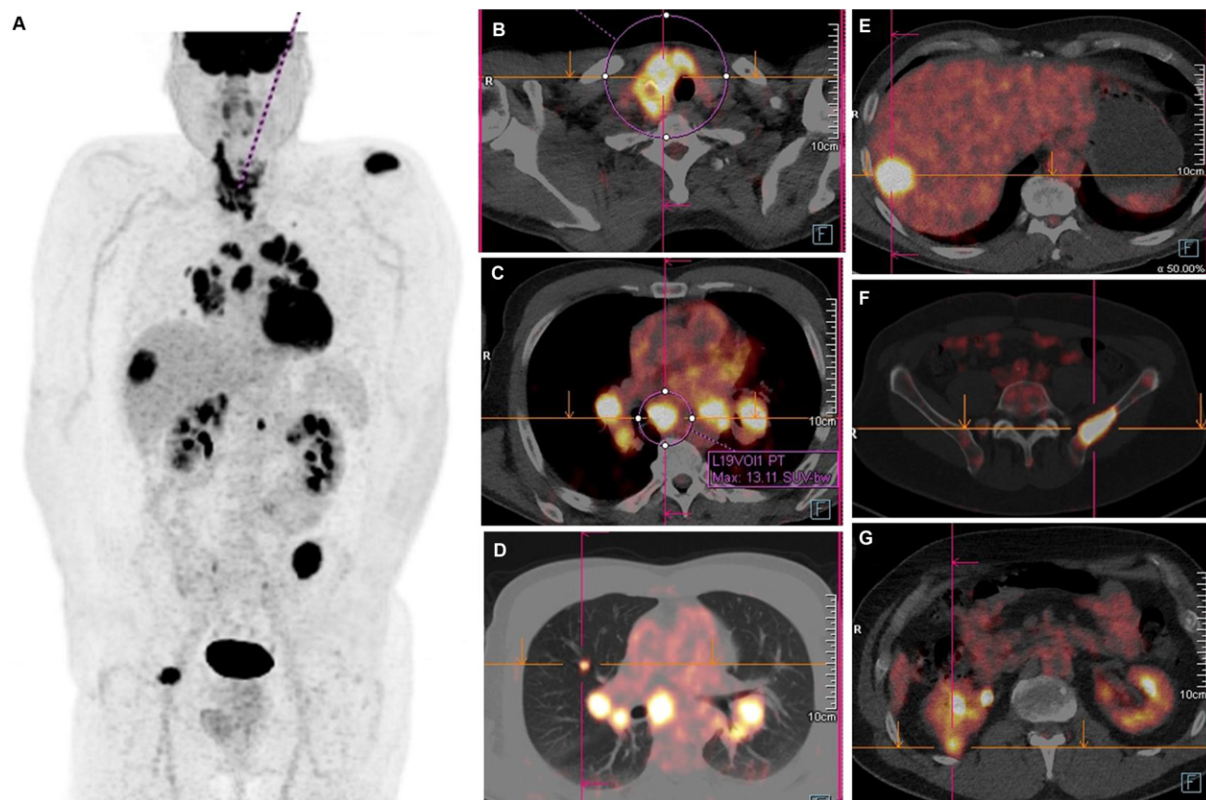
^{18}F -FDG PET maximum intensity projection image (A) and axial ^{18}F -FDG PET/CT images (B-G) in a patient with poorly differentiated thyroid carcinoma showing increasing radiopharmaceutical uptake in the thyroid (B) corresponding to the primary tumor site. Furthermore multiple lymph nodal (C), lung (D), liver (E), bone (F) and renal (G) metastases were detected by ^{18}F -FDG PET/CT.
